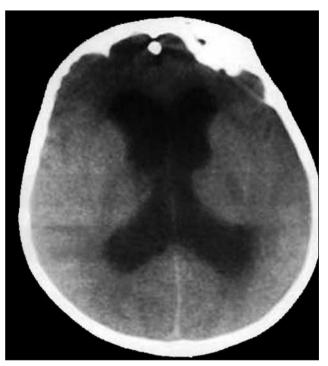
CT of the head showed obstructive hydrocephalus, with a ballooned third ventricle and a rather small fourth ventricle.
